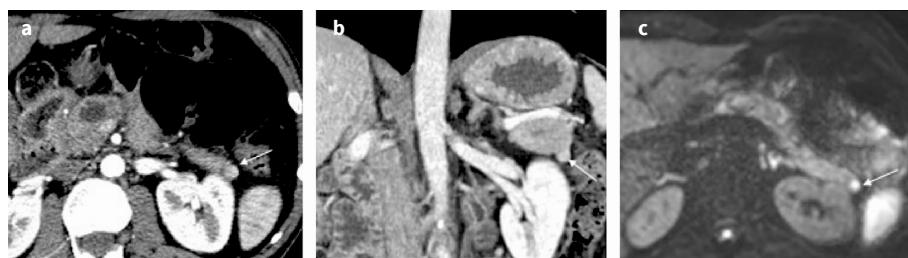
Intrapancreatic accessory spleen. An intrapancreatic accessory spleen (arrow) is seen as a focal nodular lesion showing the same enhancing pattern of adjacent splenic parenchyma in arterial (a) and venous (b) phase as well as the same signal intensity in DWI (c).
